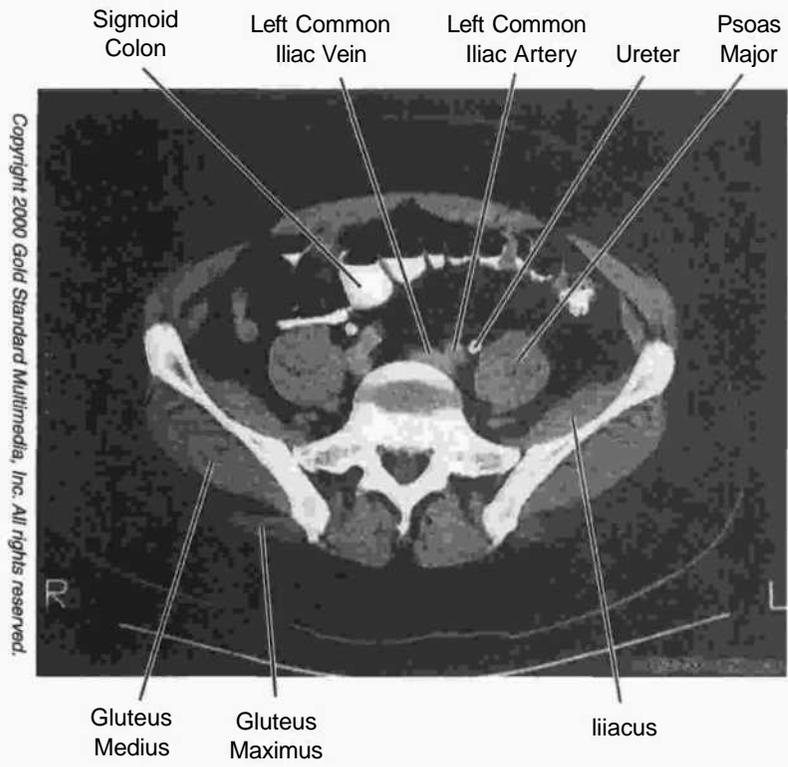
Figure IH-3-44. Abdomen: CT, S1
